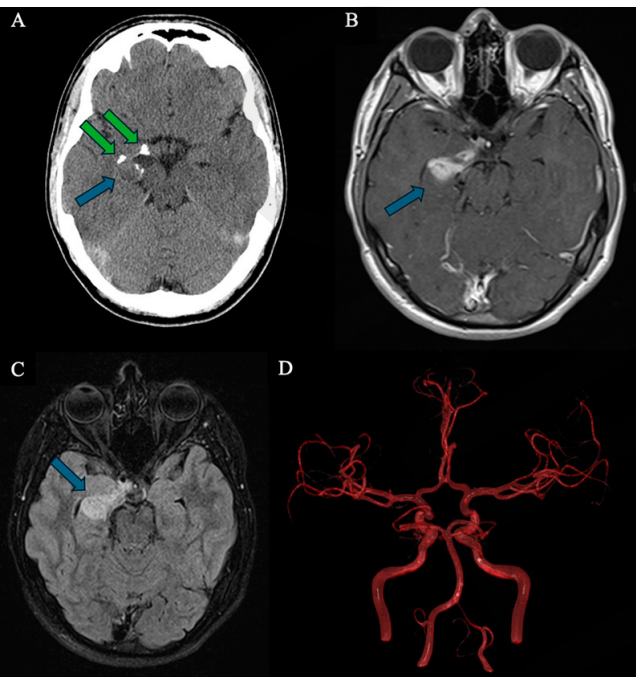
A) Computed Tomography (CT) – axial view of hypodense tumour with calcifications. Axial CT image showing a hypodense, solid-cystic lesion (blue arrow) with amorphous calcifications (green arrows) located in the medial portion of the right temporal lobe, adjacent to the hippocampal bend. B) Magnetic Resonance Imaging (MRI) – axial T1-weighted image of heterogeneous lesion. Axial T1-weighted MRI reveals a heterogeneous solid-cystic mass (blue arrow) in the right temporal lobe, measuring approximately 33 × 12 × 10 mm. C) MRI – Axial post-contrast T1-weighted image demonstrating enhancement. Axial post-contrast T1-weighted MRI shows marked enhancement of the solid portion (blue arrow) of the lesion in the right temporal lobe. D) Magnetic Resonance Angiography (MRA) – evaluation of tumour vascularity. MRA image shows no evidence of abnormal or pathological vessels surrounding the lesion
